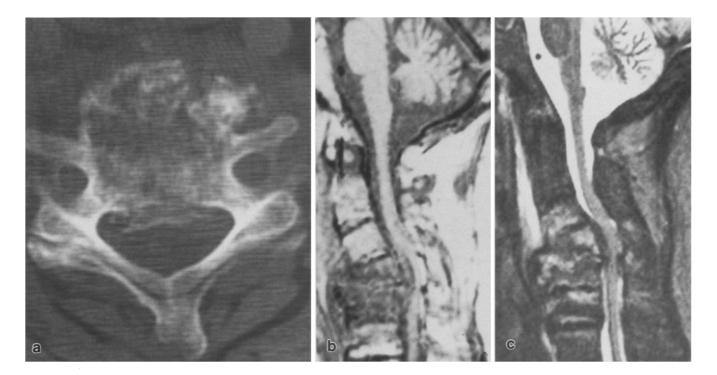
Case 1. The CT (a) shows a lytic process involving the vertebral body of C4. The MRI T1 (b) and T2 (c) weighted images confirm the lytic process extending from C4 to C6 with a soft tissue component extending into the spinal canal causing a severe extradural compression of the spinal cord
